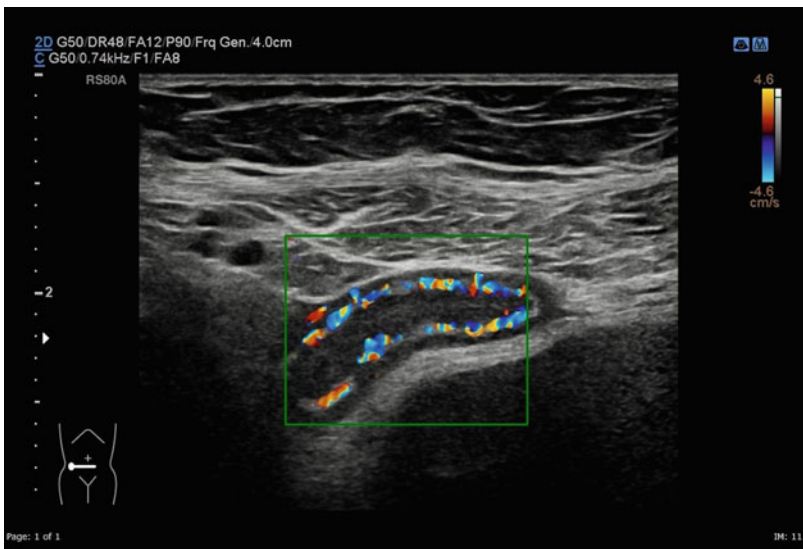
a, b Acute appendicitis. Dilated, blind ending aperistaltic tubular structure in the RIF which is tender on palpation. Hypervascularity along the wall on Doppler. Periappendiceal fluid present
